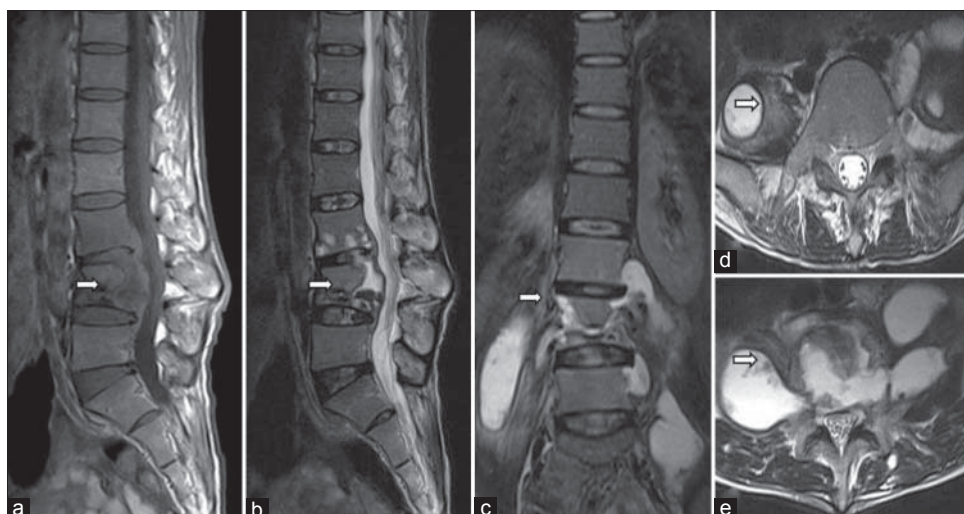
Magnetic resonance imaging lumbar spine sagittal T1W (a), sagittal T2W (b), coronal short-tau inversion recovery (c), axial T2W (d), axial T2W (e) in 30 year-old-male presenting with low grade back ache for 5 months progressing to bilateral lower limb weakness. American Spinal Injury Association Class D. Tuberculous spondylitis of L2, L3 and L4 vertebral bodies and bilateral pedicles with collapse (a-c). L3/4 disc shows diskitis, destruction and fluid intensity (b). Epidural abscess measuring 6.0 mm in maximal thickness (b). Bilateral paravertebral and iliopsoas abscess noted
